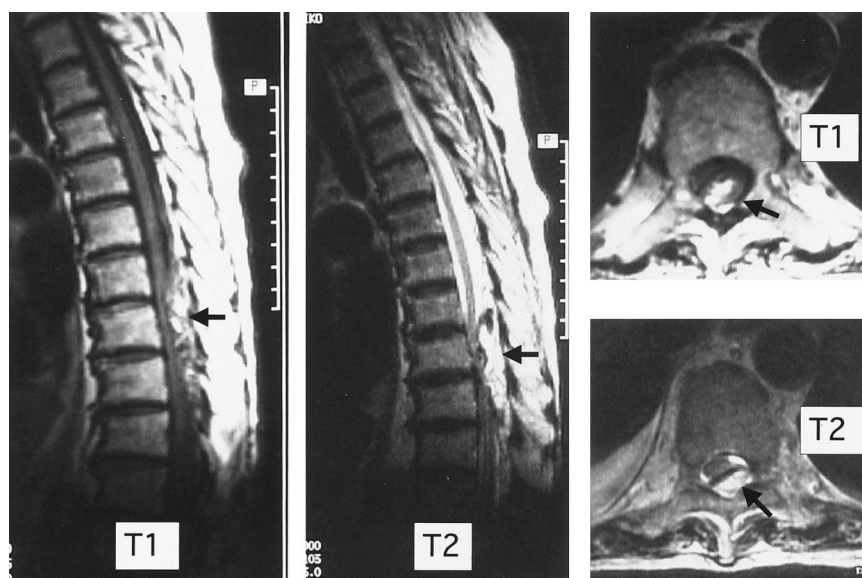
Magnetic resonance images (MRI) on postoperative day 3. Sagittal T1- and T2-weighted MRIs show a posterior hematoma extending from the Th6 to the Th9 level and compression of the spinal cord. Arrows indicate the hematoma at the Th7 level in axial and sagittal MRIs.
